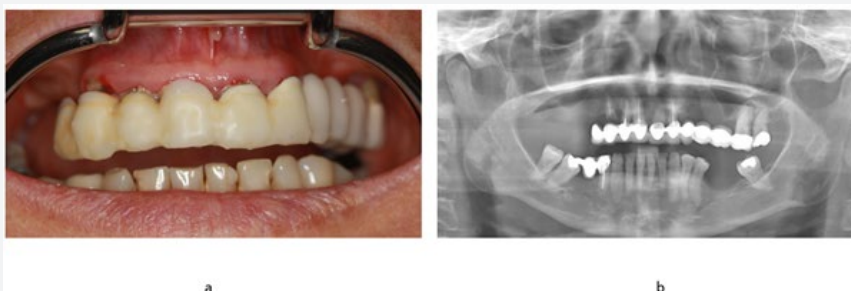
The clinical photograph and panoramic radiograph of patient at presentation.
